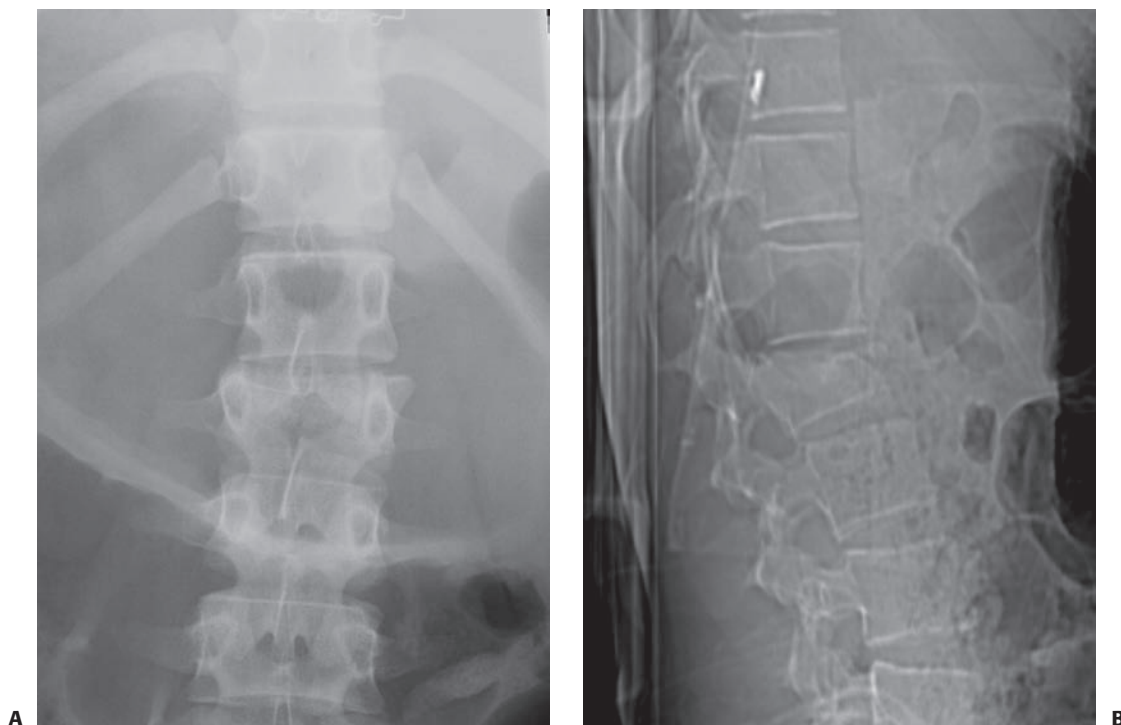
Burst fracture. A: This teenage patient presented with loss of vertebral body height associated with a motorcycle accident after jumping more than 20 ft. His neurologic examination was intact. B: CT scan confirmed a burst fracture component with very little retropulsion into the spinal canal.
